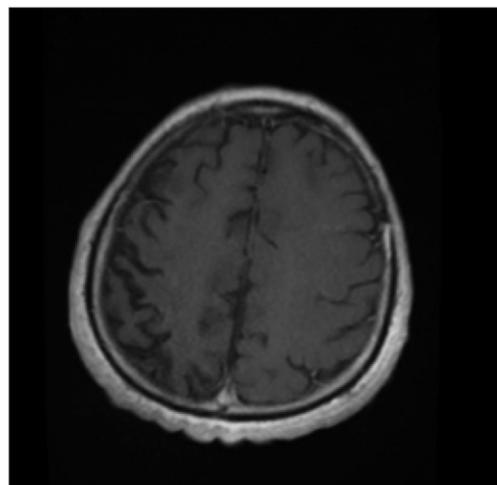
Unidentified bright objects (UBOs) on axial post-contrast T1-weighted MRI demonstrated no contrast enhancement.
